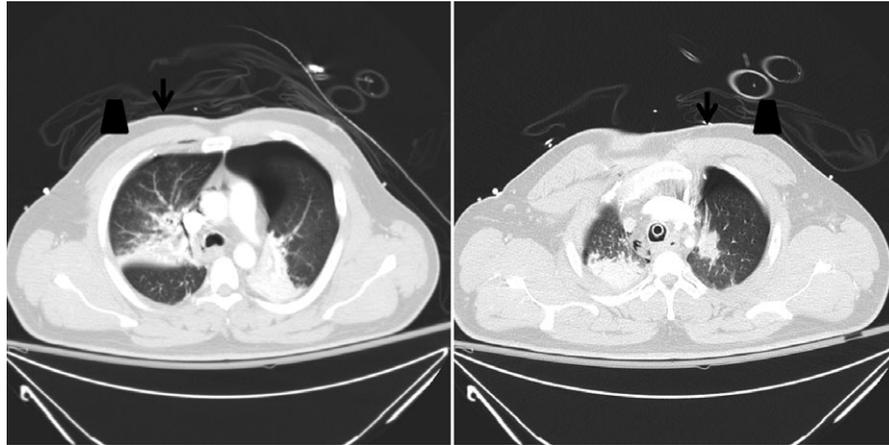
Images of chest CT from the missed significant PTX. The image on the left shows the patient's right lung still adjacent to the anterior chest wall. The PTX on this side was lower. You can see the beginning of it in the image. The image on the right shows the patient's left lung adjacent laterally. Transducer placement in this patient was at this location secondary to the needle decompression in place more medially. The arrow indicates the site of the needle decompression on each side of the chest and the trapezoid indicates the site where the ultrasound was performed. CT = computed tomography; PTX = pneumothorax.
